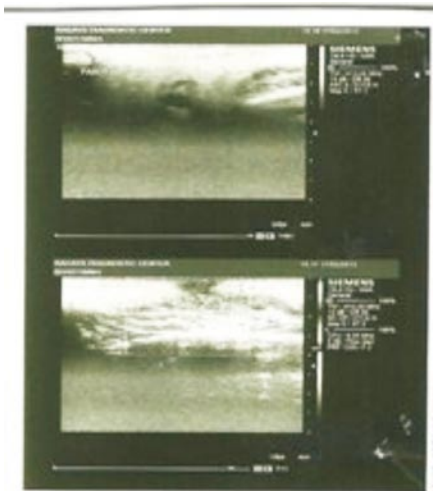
Ultrasound showing resolving cysticercosal lesion.
